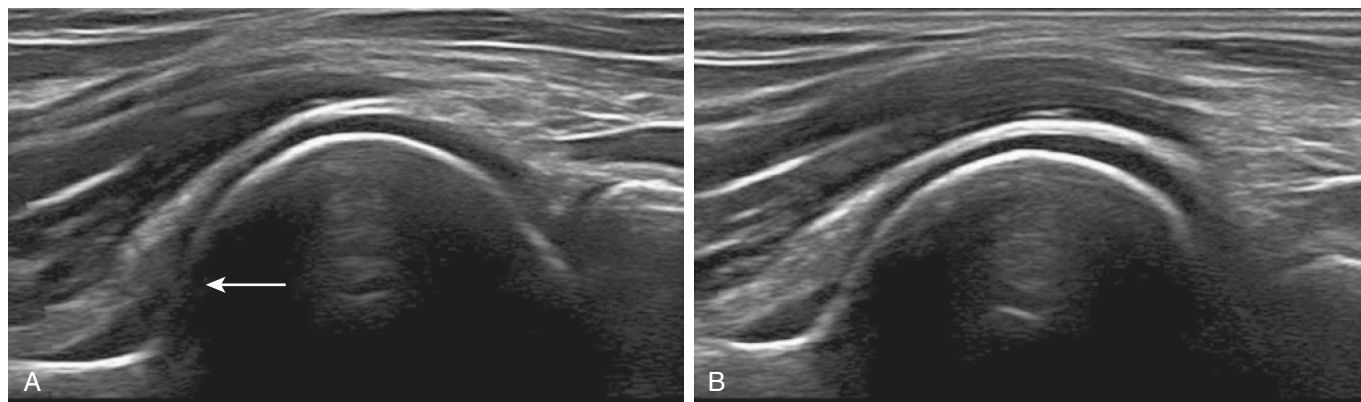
Ultrasound shows a bone pseudodeflect artifact. A, A bone pseudodeflect artifact (arrow) is visible on the proximal aspect of the capitulum humeri. B, The artifact is corrected by transducer manipulation that redirects the beam obliquely.
